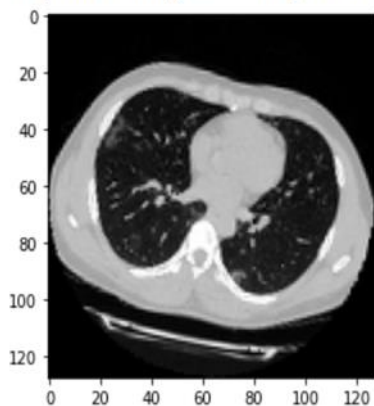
Visualisation of Augmented CT scan
